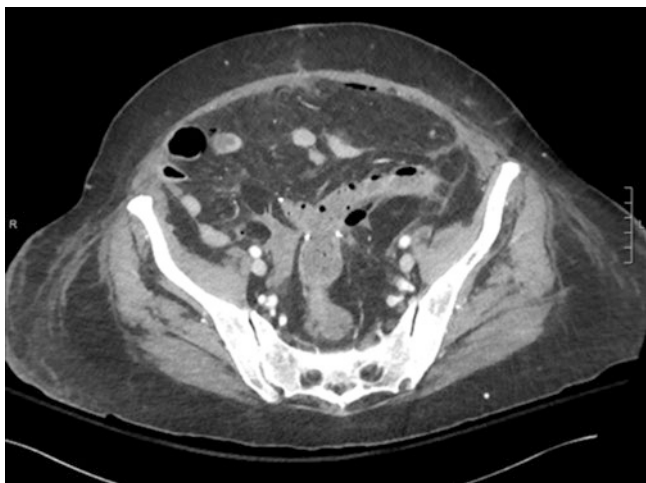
Colorectal anastomotic leak: CT image of a patient who developed anastomotic leak on postoperative day 5 after undergoing sigmoid colectomy for diverticulitis complicated by colovaginal fistula. She required operative intervention for washout and takedown of the anastomosis and creation of an end colostomy
